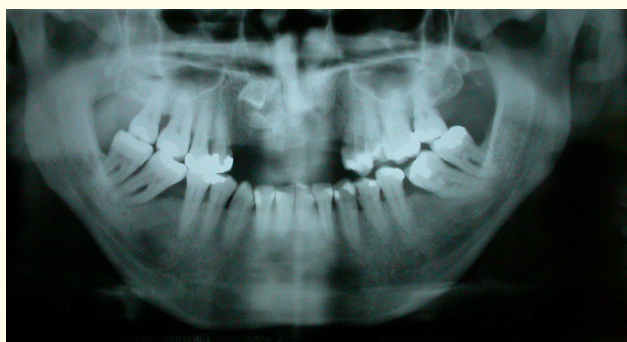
Initial radiographic aspects (panoramic radiograph).
